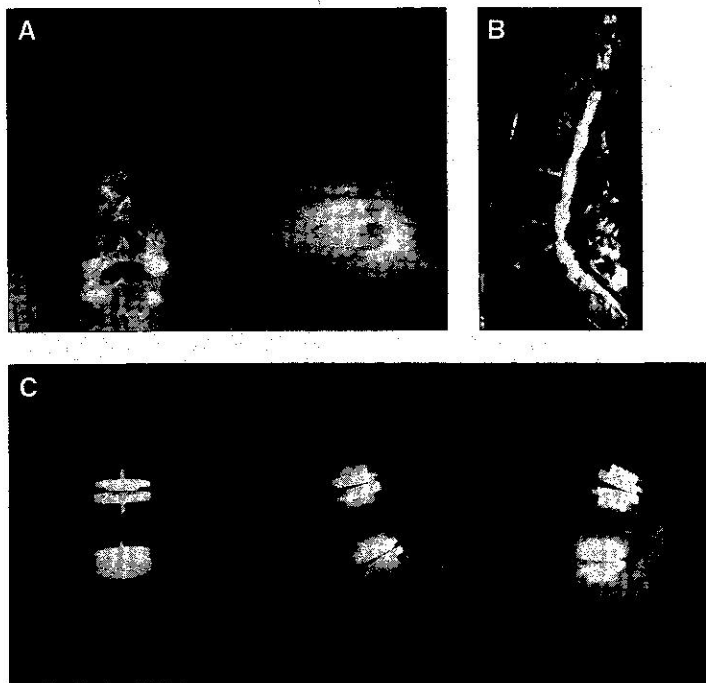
Case 2 preoperative radiographs (A), and MRI (B), and postoperative anteroposterior and flexion extension radiographs (C). Note the dynamic correction of local scoliotic deformity at L3-5 due to asymmetric disc collapse.
